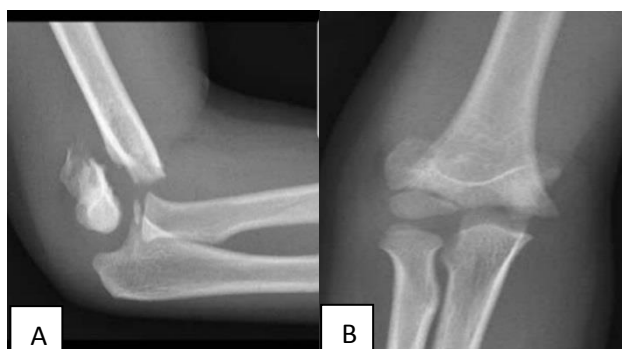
Radiograph of the elbow showing Gartland type III fracture. (A) Lateral view, (B) anteroposterior view.
